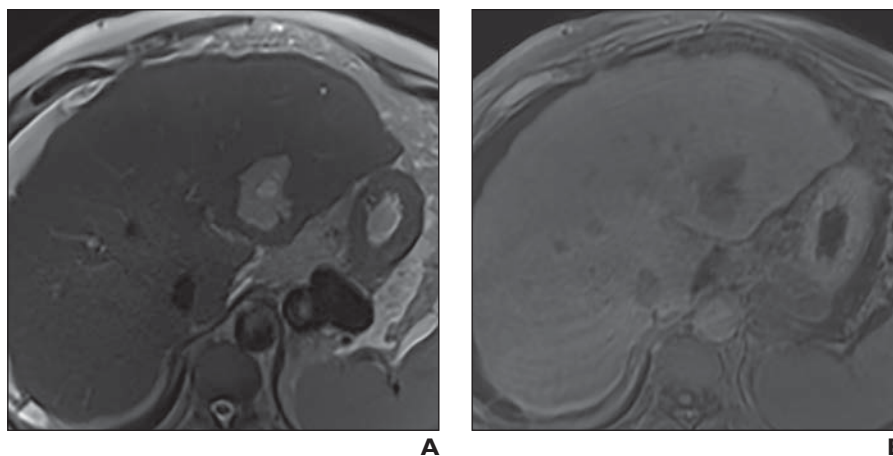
55-year-old man with alcoholic cirrhosis with hepatocellular carcinoma diagnosed on outside study. Example of hemangioma with ringlike enhancement. Dominant mass in segment II–III has lobulate contour, high signal intensity on T2-weighted image with central focus of even higher signal intensity, and corresponding diminished signal intensity on T1-weighted image. After contrast infusion, there is continuous rim of enhancement, which exhibits centripetal filling on late phase images without complete filling of central portion. This pattern of enhancement may be seen in cirrhotic liver and is likely related to fibrosis around fluid-filled hemangioma and to early hyalinization.
